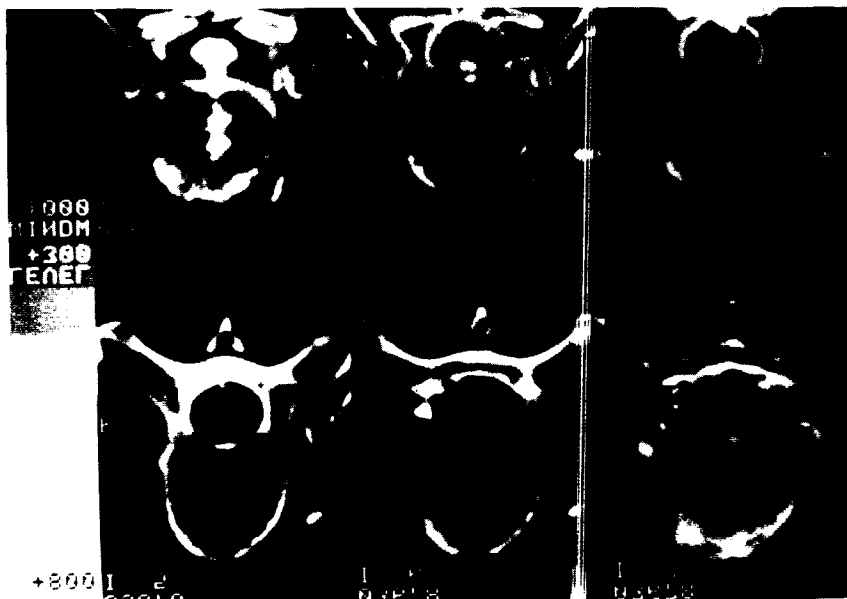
Case 3. CT scan of dorsal spine showing calcified disc material extending deeply into the spinal canal as a large "button" (CT cuts 1-7, 1-8, 1-9, 1-10).
